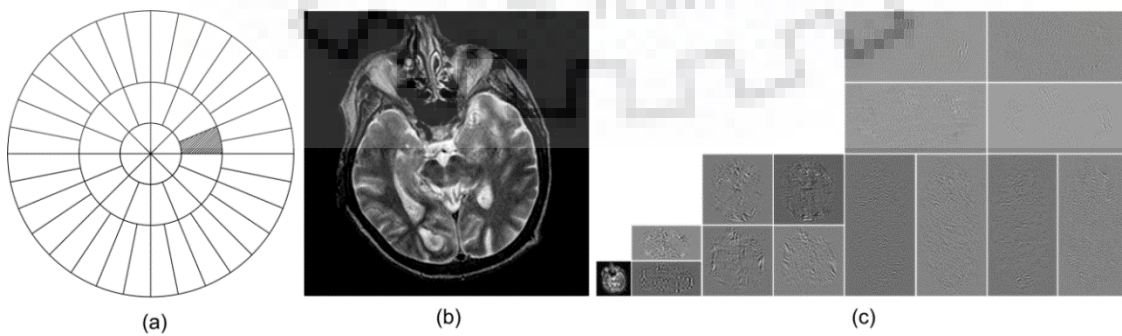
(a) The tiling of the polar frequency domain. The dashed wedge corresponds to the frequency transform of the element function. (b) Source MR image (c) Subbands after DRT decomposition of source image with support ( $c = 1$ ) and degree ( $d = 4$ )
